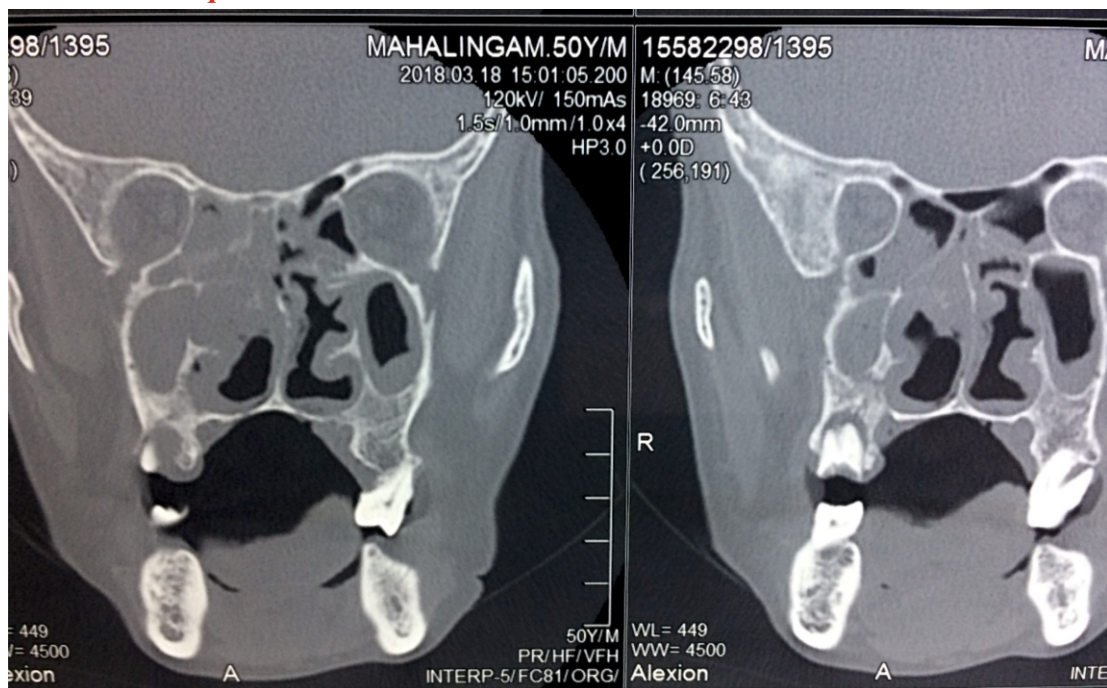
CT scan showing mass involving right maxillary sinus , extending into ethmoids.
